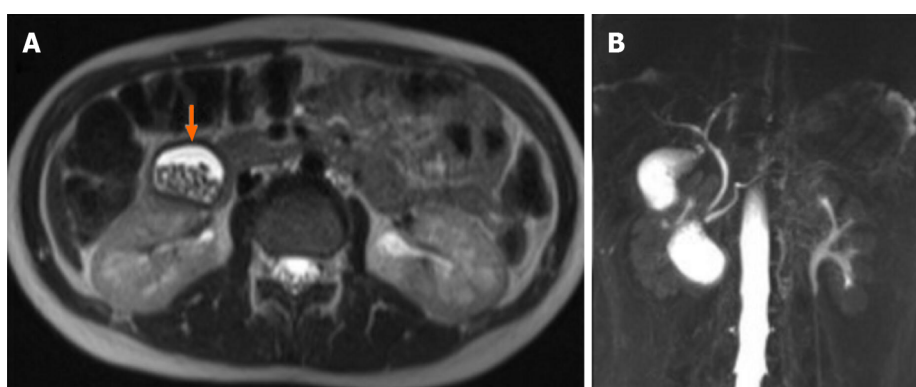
Magnetic resonance imaging of case 3. A: An oval heterogeneously hyperintense lesion containing multiple stones and located in the second part of the duodenum; B: Cholangiographic reconstruction showed normal gallbladder and intra- and extrahepatic bile ducts.
